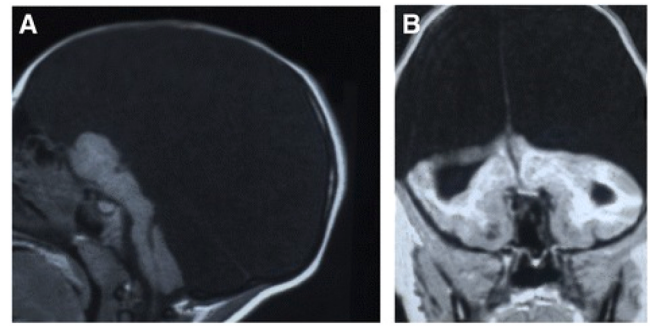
Brain of hydranencephalic individual with no cortex. Case of a hydranencephalic child (Pavone et al., 2014) with no cerebral cortex remaining according to clinical neuroradiological assessment. Sagittal (left) and coronal (right) T1 MRI images. Senior author (R.F.) confirmed that the patient did not have any cerebral cortex remaining in personal communication. A clinician who saw the child affirmed that the patient was not in a vegetative state in personal communication. Another affirmed that she “definitely felt emotions”. Image reused under CC-BY.
